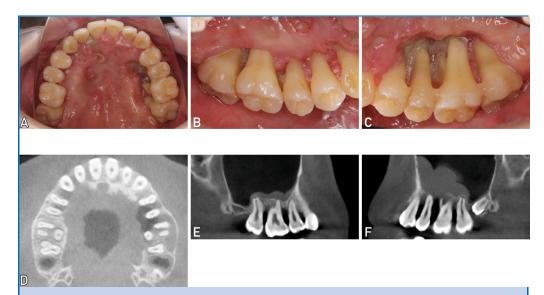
Initial oral examination and radiographic findings of maxillary alveolar bone resorption. (A-C) Intraoral photographs showing extensive palatal aphthae with severe root exposure and alveolar bone resorption confined to the palatal region: occlusal view (A), right palatal view (B), and left palatal view (C). (D-F) Cone-beam computed tomography images demonstrating severe alveolar bone loss: axial view showing extensive bone resorption in the bilateral posterior regions (D), and sagittal views of the right (E) and left (F) molar regions showing bone loss extending to the root apices.
